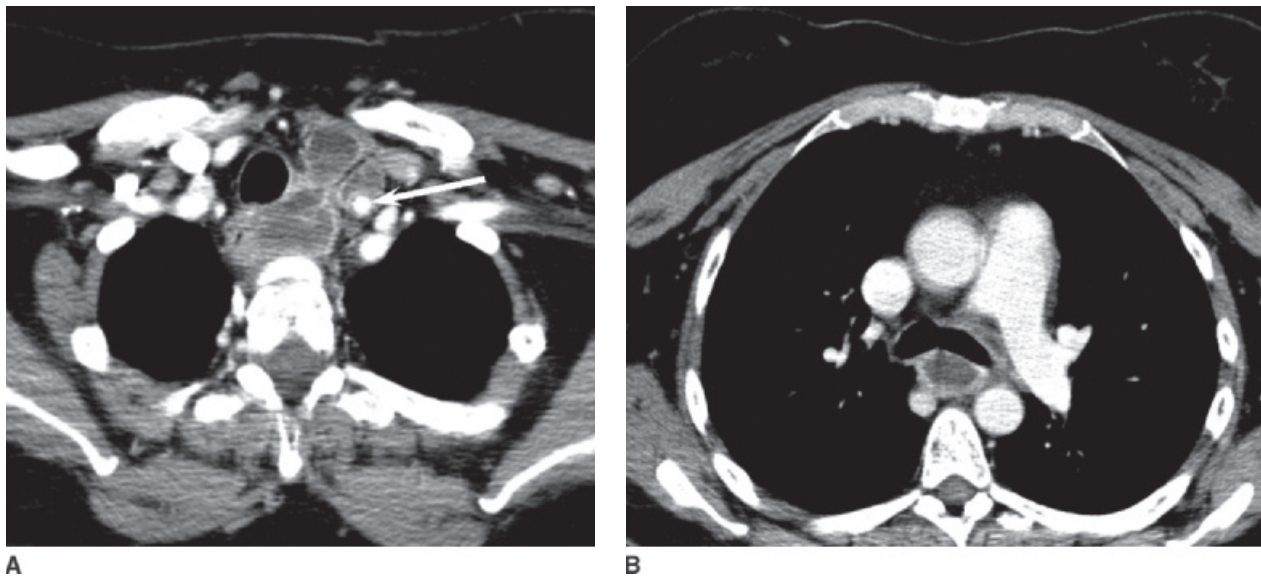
Danger space abscess. A: Axial contrast-enhanced CT shows a multilocular abscess of the lower neck involving the central compartment, the retropharyngeal space, and carotid sheath, with abscess surrounding the common carotid artery (*arrow*). B: More inferior image shows the retropharyngeal component of the abscess extending deep into the mediastinum, below the level of the T4 vertebra. Because the retropharyngeal space extends only to T2–T4, this infection must be located in the danger space, which extends to the diaphragm.
